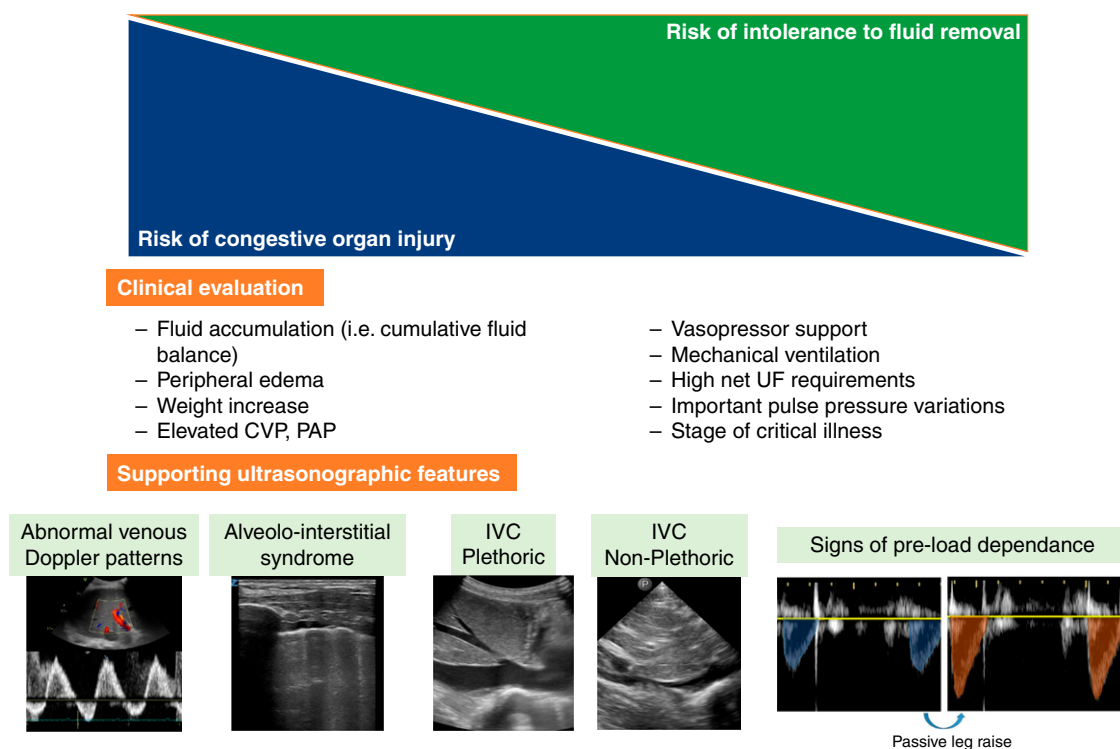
Evaluating the risk and benefit of fluid removal involves a multimodal assessment combining multiple sources of clinical information that can be supported by the identification of point-of-care ultrasound features suggestive of organ congestion or preload dependence. CVP, central venous pressure; PAP, pulmonary artery pressure; UF, ultrafiltration.
